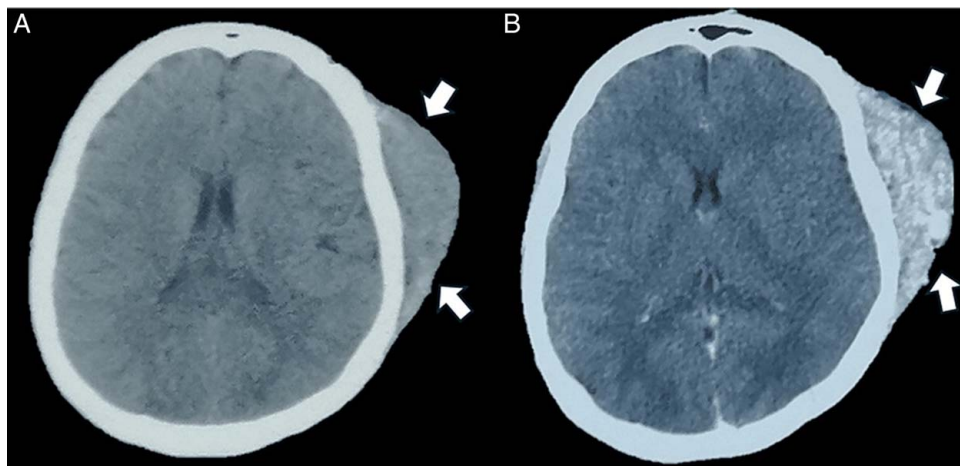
Computed tomography (CT) scan of the brain demonstrating a scalp arteriovenous malformation (white arrows): (A) Plain CT scan and (B) CT scan with heterogeneous enhancement following intravenous contrast administration.
